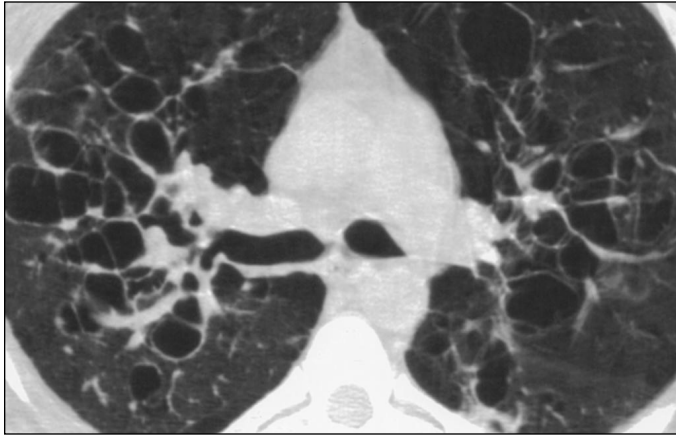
Williams-Campbell syndrome in 27-year-old man with recurrent infection. Thin-section CT scan (1.5-mm collimation) shows varicoid and cystic central bronchiectasis associated with normal-caliber main bronchi.
